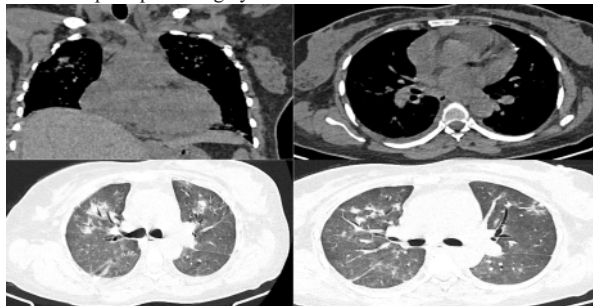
Multi slice CT Pulmonary Angiogram shows patchy consolidation, Minimal bilateral pleural effusion, Cardiomegaly, Minimal pericardial effusion.
